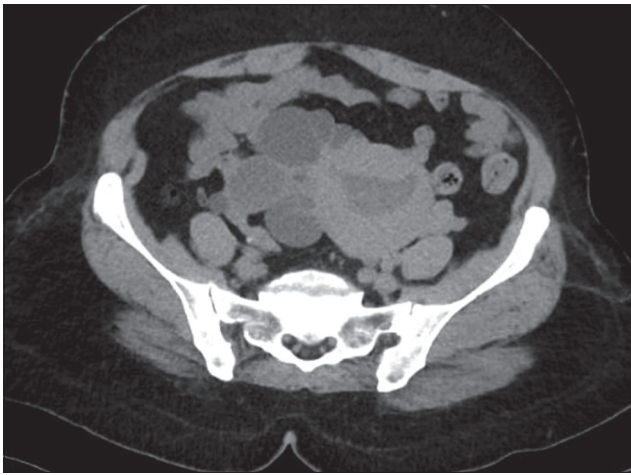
Contrast-enhanced computed tomography of the pelvis showing the uterus with endometrial collection and multiple adnexal cysts
